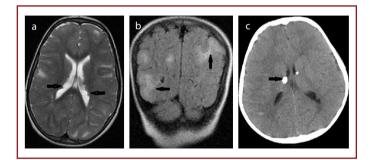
Axial T2 weighted (a) image shows low-signal subependymal nodules (black arrow) with periventricular placement and hyperintense cortical tuberosclerosis. In coronal FLAIR (b) image, cortical hyperintense tuber (black arrow) is clearly selected. Axial CT image (c) shows calcified subependymal nodule appearance (black arrow).
